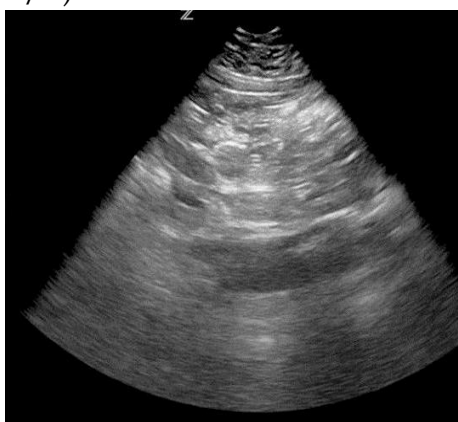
Transverse abdominal ultrasound image
